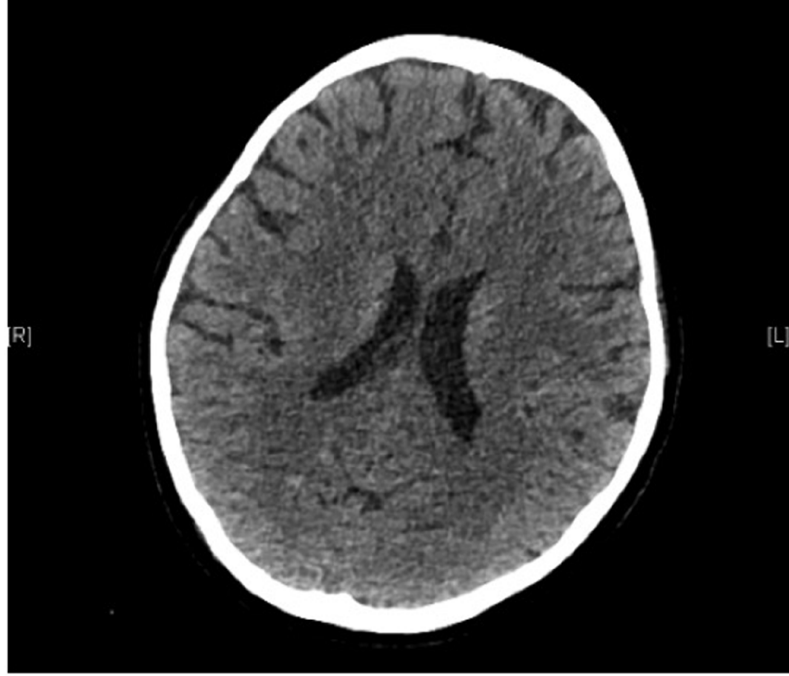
head CT showed the sulci swelling and unclear structure.
